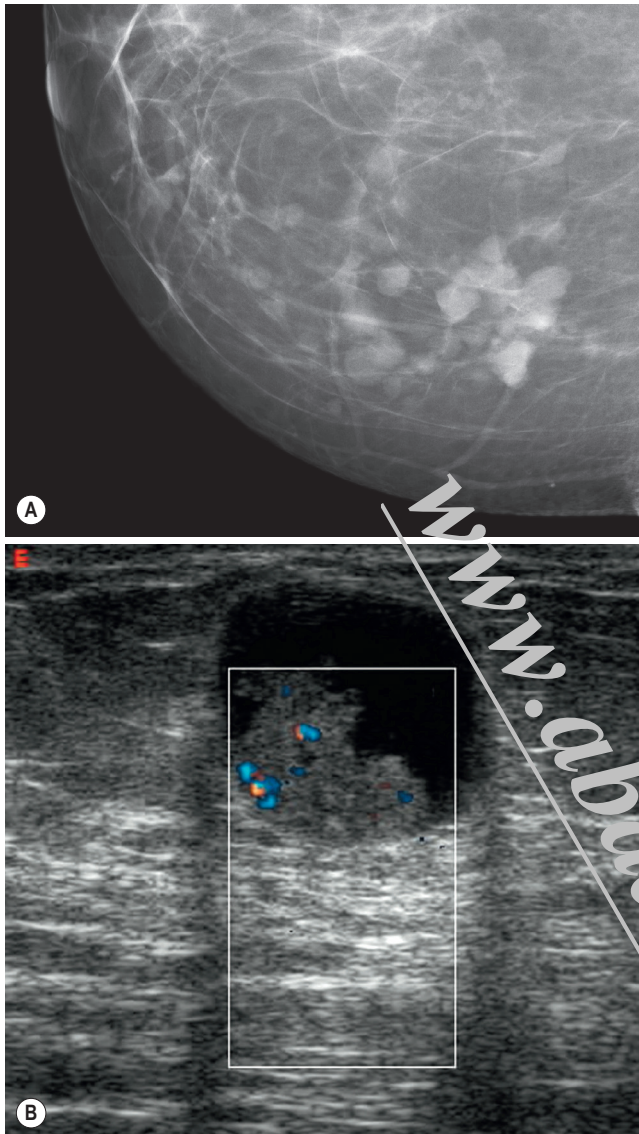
Multiple Small Papillomas. (A) Papillomas are frequently well defined on mammography, although part of the mass may have an irregular or ill-defined contour. (B) On ultrasound, the presence of a filling defect within a cystic structure suggests the diagnosis. Colour Doppler can be useful for distinguishing debris within a cyst from a soft-tissue mass.
